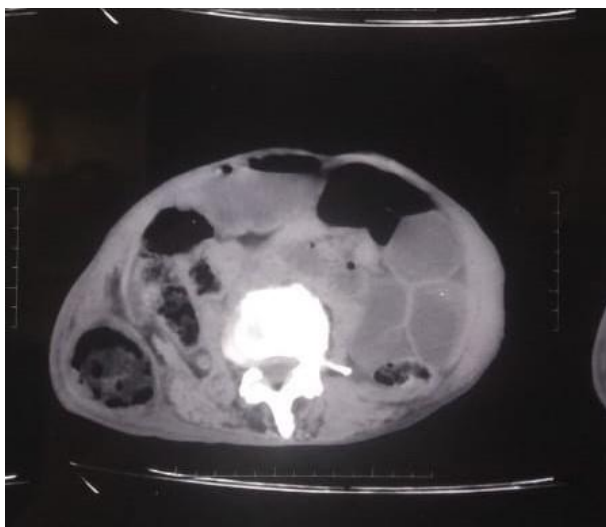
CT abdomen showing right lumbar hernia with bowel as content and dilated small bowel loops.
